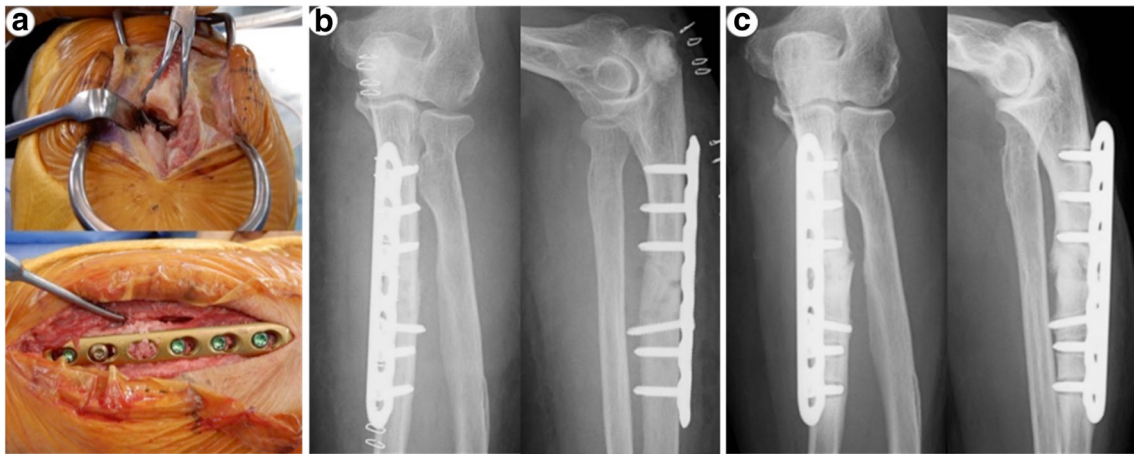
a Intraoperative photographs showed cortical thickening and osteosclerotic changes at the fracture site, and an autologous cancellous bone graft from the ipsilateral olecranon was inserted. b Postoperative plain radiography. c Plain radiography of 1 year after surgery
